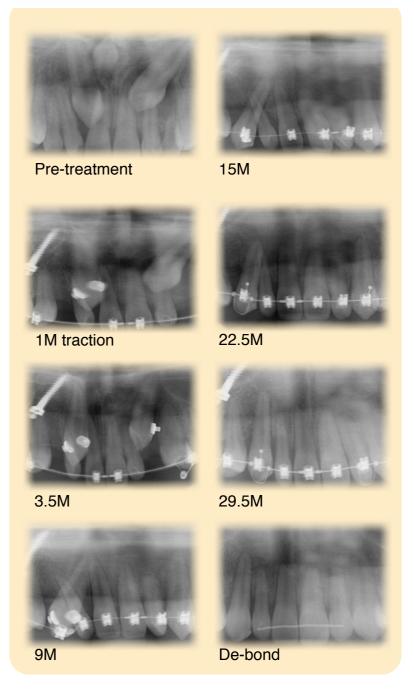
X-ray films showed the progress of transposition correction.
